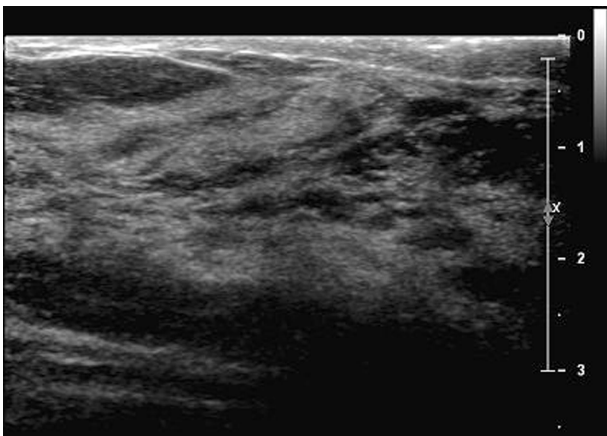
Ultrasonographic demonstration of breast cancer.
